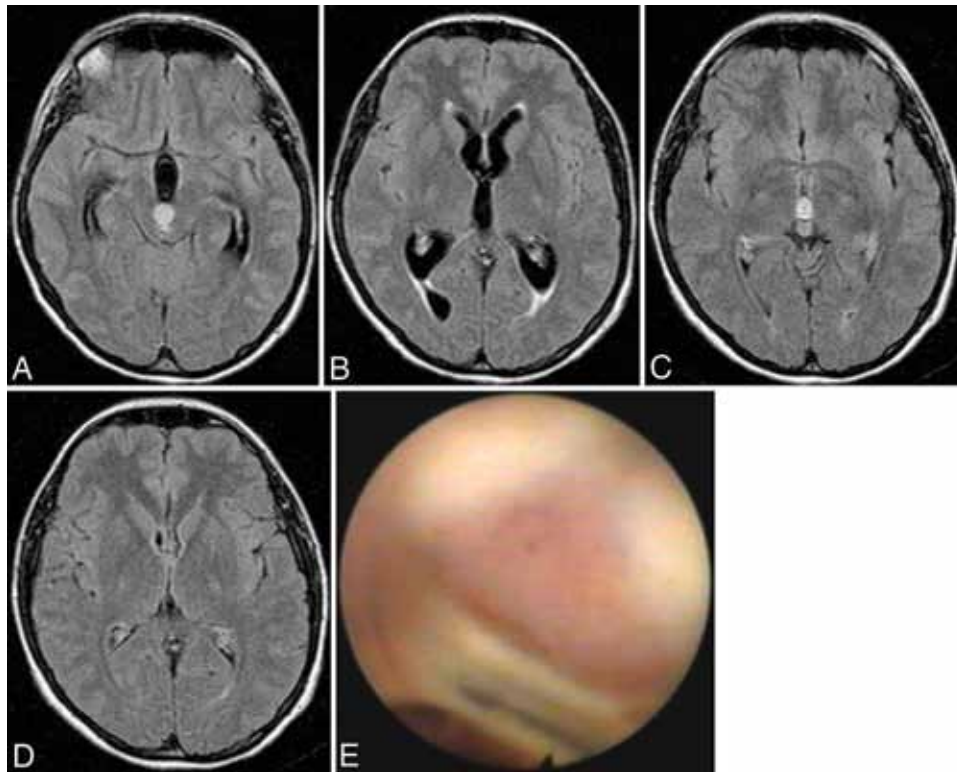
Images obtained in a 33-year-old woman with a fibrillary astrocytoma associated with hydrocephalus. A–D: Axial FLAIR MR images. Preoperative images showing the tumor occluding the aqueduct (A) and hydrocephalus (B). Images obtained 1 year after the biopsy and ETV, showing stable tumor (C) and reduction of ventricular diameters (D). E: Endoscopic view of the tumor arising by the posterior commissure.
